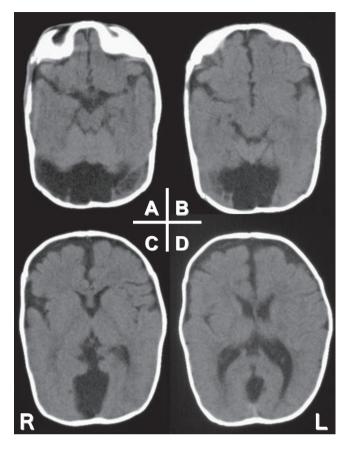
Brain computed tomography showed hypoplasia of the cerebellar vermis (A,B) and a cyst communicating with the 4th ventricle (B,C,D), suggesting DWS.
